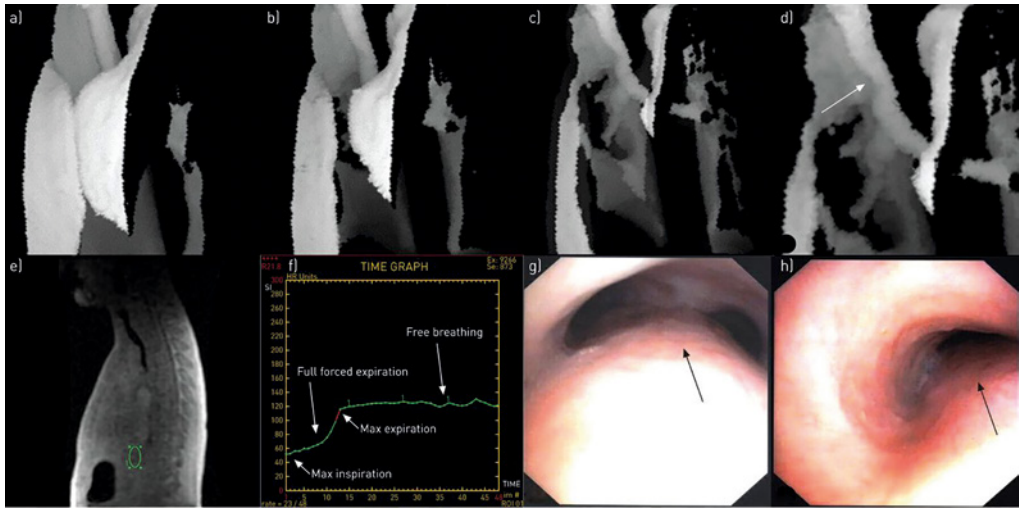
Dynamic magnetic resonance imaging (a-e), respiratory waveform (f) and bronchoscopy images (g, h) in patient C. (a-d) Three-dimensional volume rendering at different time points during the forced expiration manoeuvre. Note the trachea impression above the carina (d) indicated by a white arrow. (e) Sagittal view with green region of interest to assess signal intensity changes according to the breathing cycle. (f) Correspondent signal intensity changes (approximate respiratory waveform) over time, where y-axis represents signal intensity and x-axis the time. Note the inverted relationship between volume of air in the lungs and signal intensity. The patient started the forced expiratory manoeuvre from maximum inspiration, which showed the lowest signal intensity, until maximum expiration, which had the greatest signal intensity. (g,h) Screen shots of the bronchoscopy evaluation in the same patient show bulging of the pars membranacea (black arrows) in addition to the anterior impression (h) just above the carina caused by the innominate artery, which corresponds to the tracheal impression as shown on image (d).
